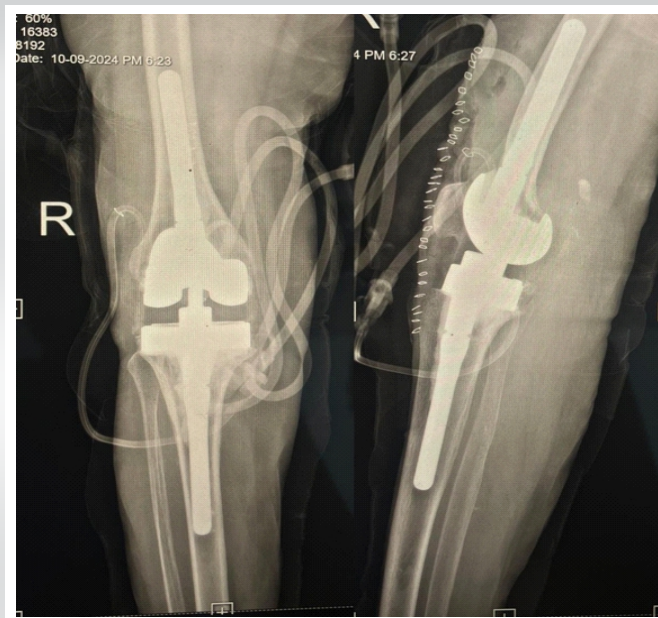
Intraoperative/radiographic image showing the revision implants, comprising press-fit diaphyseal stems and a constrained component with tibial wedges.
